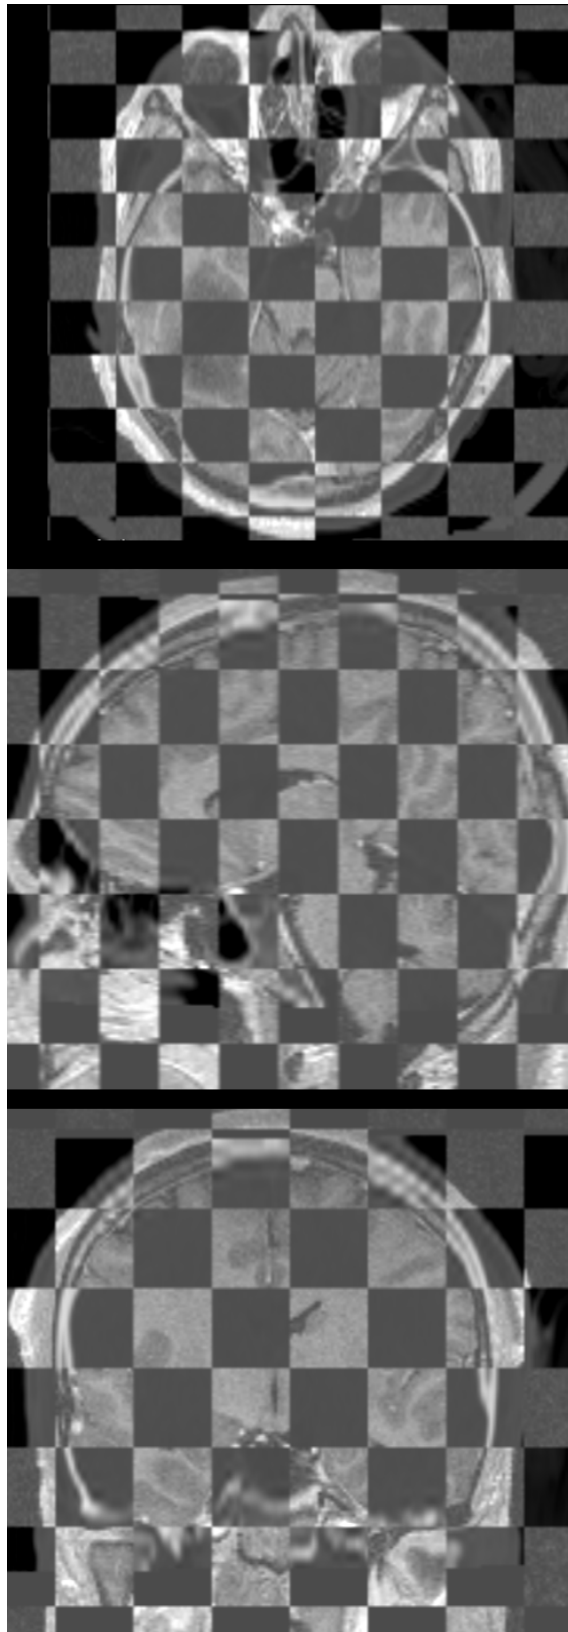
A checkerboard-filtered registered CT and MR images with transparency alpha value 0.5.
